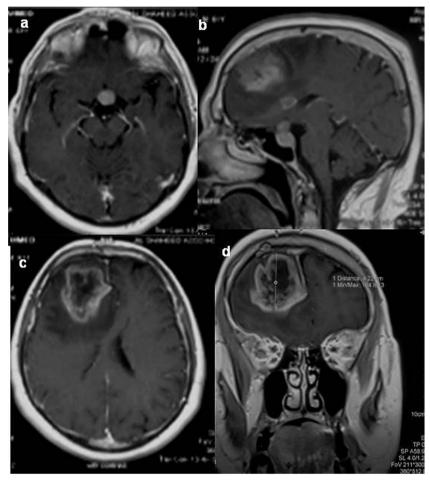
(a) Preoperative axial magnetic resonance imaging (MRI) of the brain showing a well defined sellar tumor with homogeneous contrast enhancement after gadolinium (Gd) administration. (b) Sagittal contrast-enhanced T1-weighted MRI scan demonstrates a suprasellar extension of the pituitary adenoma and revealing a further mass lesion in the right frontal lobe. (c and d) Axial and coronal Gd-MR images demonstrating the supratentorial mass lesion with ring-like enhancement, heterogeneous necrotic appearance and dense vasogenic peritumoral edema, well compatible with a GBM.
